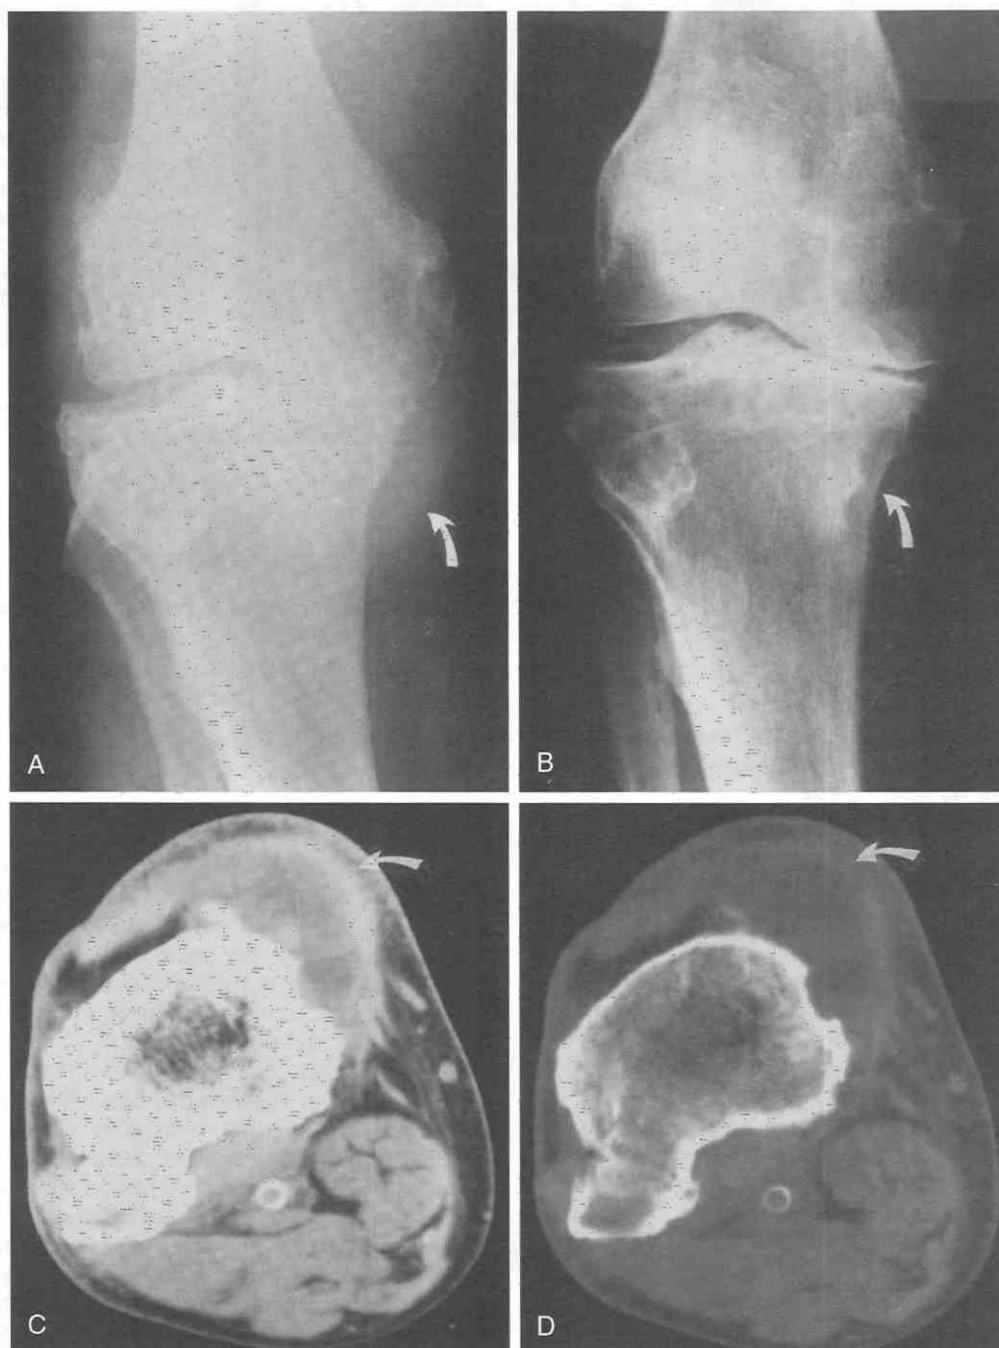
Meniscal cyst. *A* and *B*, Anteroposterior radiographs of the right knee show osteoarthritis with a soft tissue mass medially causing pressure erosion of the proximal medial tibia (*arrow*). *C* and *D*, CT scan shows a fluid-filled mass eroding the adjacent tibia (*arrow*).
